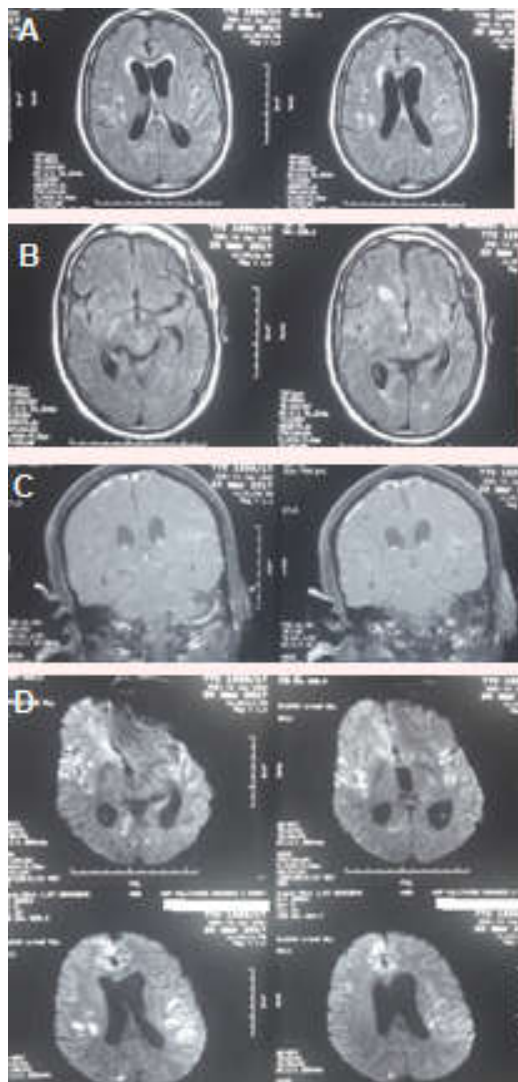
Cerebral MRI in FLAIR sequences (A, B), with Gado injection (C) and diffusion (D) showing multiple FLAIR hyper signals, without contrast enhancement outside a temporal hyper signal with nodular enhancement
